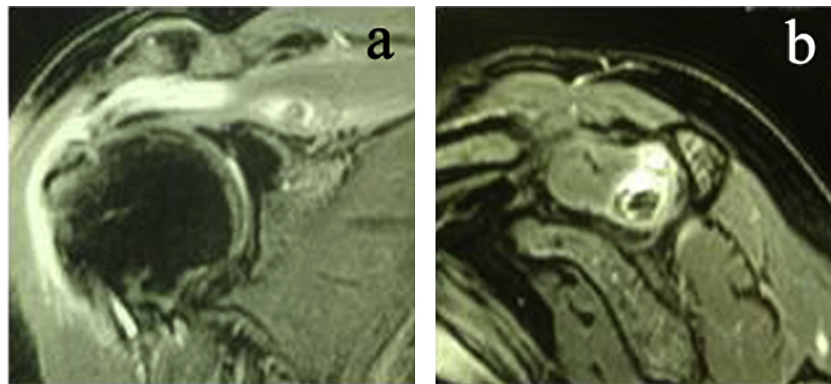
(a, b) MRI images of calcific supraspinatus intramuscular deposit.
